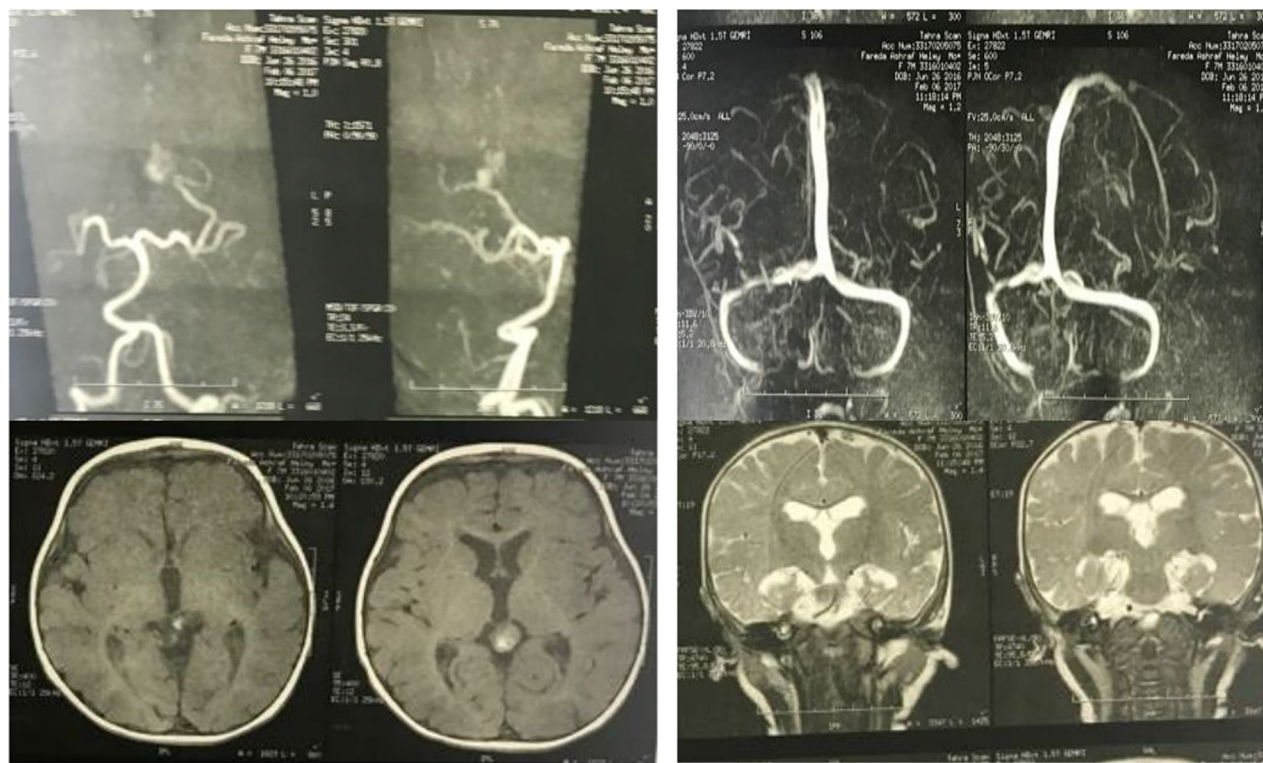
Postoperative MRI brain with MRA and MRV showing complete occlusion of the VGM
